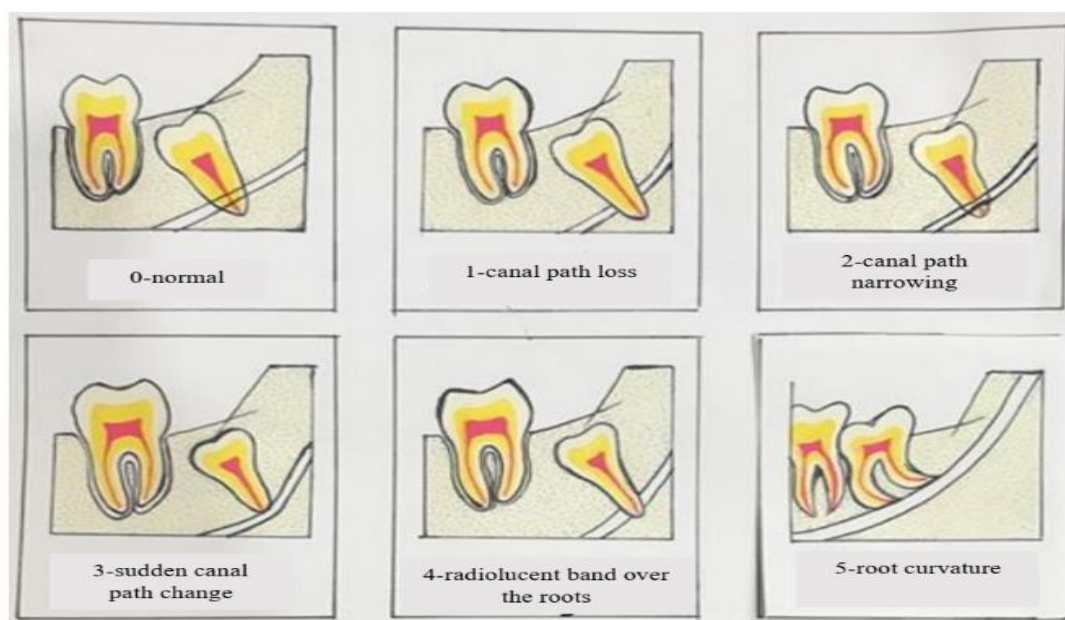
Panoramic radiographic signs
